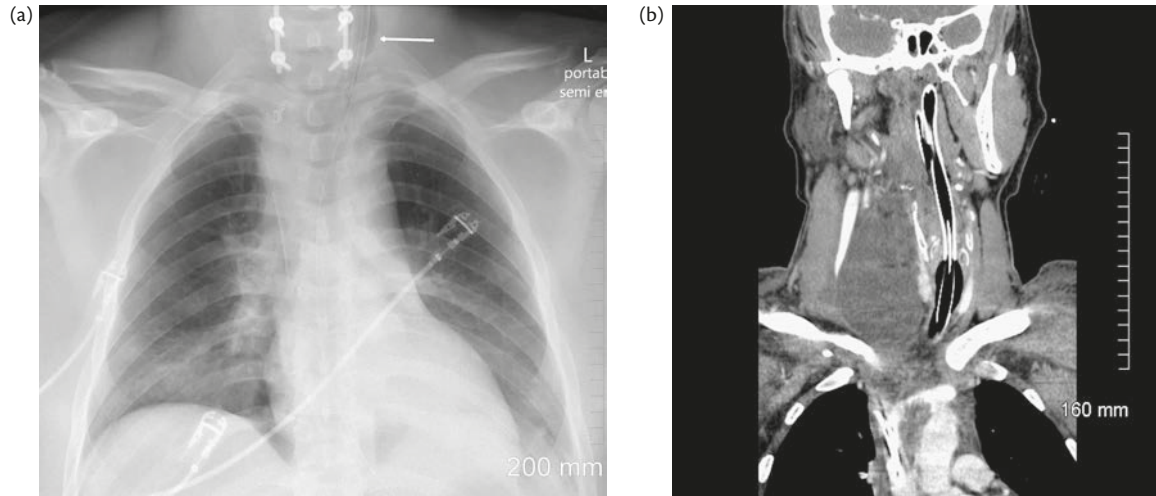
Case 4. (a) X-ray; (b) CT scan.
